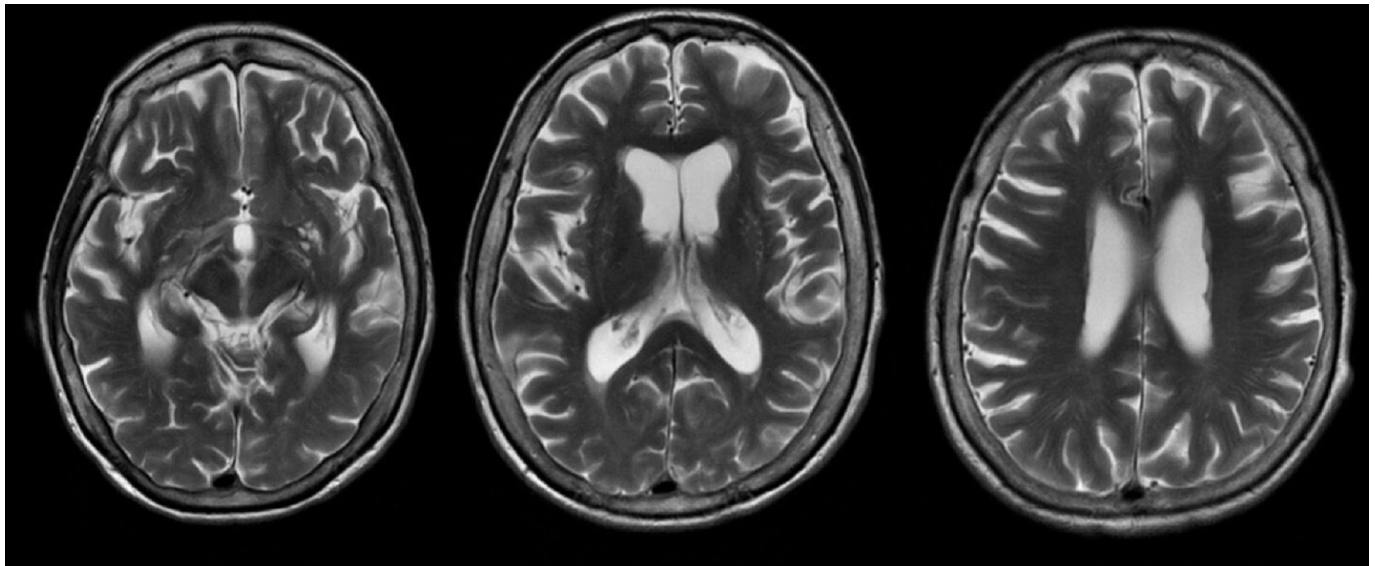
Three-Tesla cranial MRI at day 18 did not reveal evidence for structural brain damage. Exemplary axial slices of T2-weighted sequences are shown. Additional diffusion-weighted and contrast-enhanced sequences were also unremarkable. (Fig created by Sebastian Berger.)
